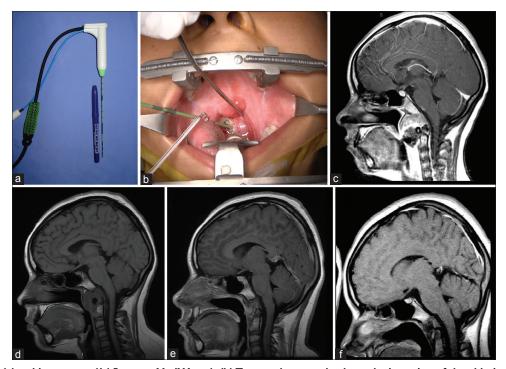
Case 4: (a) a thin antenna (14.5 gauge; MedWaves). (b) Transoral approach where the insertion of the ablation antenna toward the lesion is noted. (c) Magnetic resonance image enhanced in sagittalT1 (with contrast) where a clivus preablation lesion can be observed. (d) Magnetic resonance image enhanced in sagittalT1 8 months after ablation. (e) Magnetic resonance sagittalT1-enhanced image 14 months after ablation. (f) Sagittal magnetic resonance image enhanced in T1 30 months after ablation
